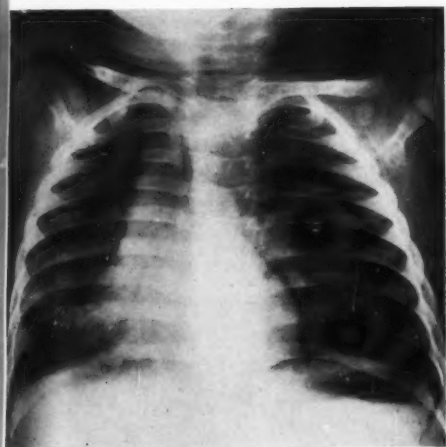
Radiograph taken one month after removal of the foreign body. The mediastinum has now moved to the right, the diaphragm is slightly elevated and the ribs are crowded.
